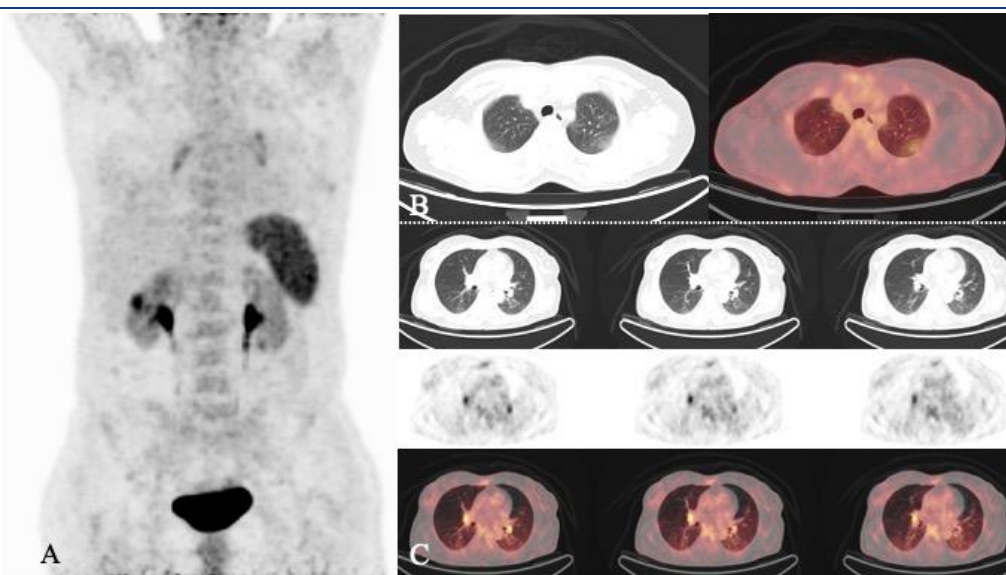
[⁶⁸Ga]Ga-Pentixafor PET/CT; A) MIP, B) an example of GGO avid [⁶⁸Ga]Ga-Pentixafor in the periphery of the left Apico-posterior segments of the upper lobe. C) Three consecutive PET/CT slices showing bilateral hilar lymph nodes with Pentixafor avidity
